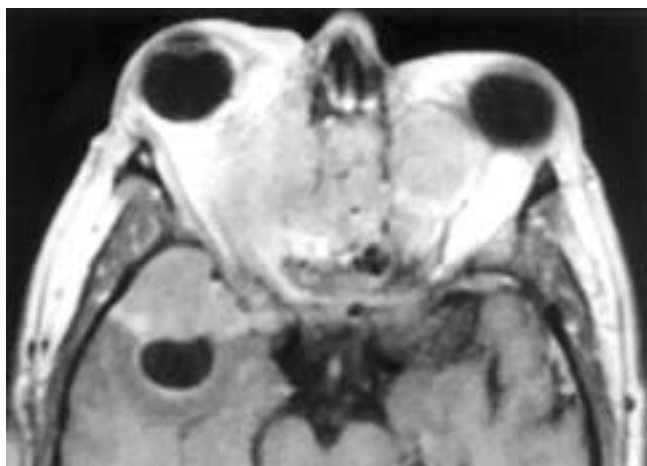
Axial T1-weighted, contrast-enhanced MR image on a patient who previously had a craniofacial resection for an olfactory neuroblastoma. There is a large enhancing recurrence extending into the orbits and the anterior cranial fossa. Note the small, broad-based cyst at the intracranial margin of the tumor. Such a cyst is highly suggestive of the diagnosis. This patient had an olfactory neuroblastoma.
